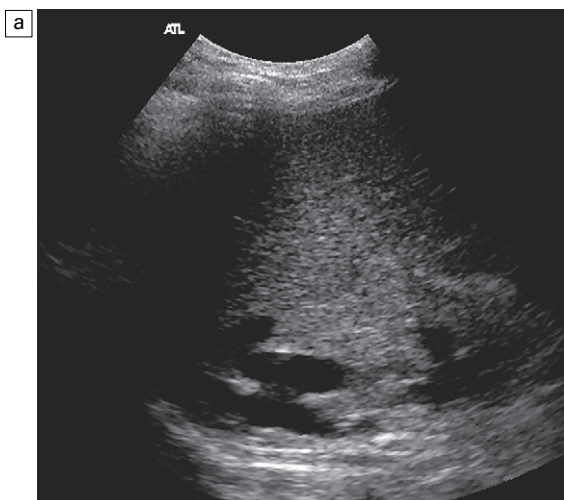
(a) A real time image of the upper caval region in a liver transplant patient with a 'piggyback' caval anastomosis, showing the native cava posteriorly and the donor cava just anterior to it; (b) colour Doppler image of the same anastomosis.
